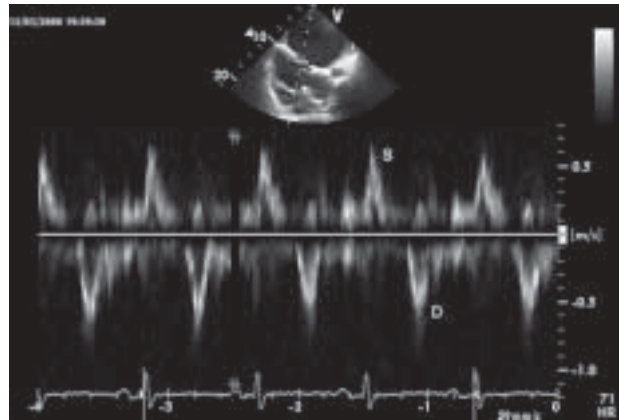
Pulsed wave Doppler revealing flow in pseudoaneurysm orifice: toward pseudoaneurysm cavity in systole (S) and toward left ventricle in diastole (D)
